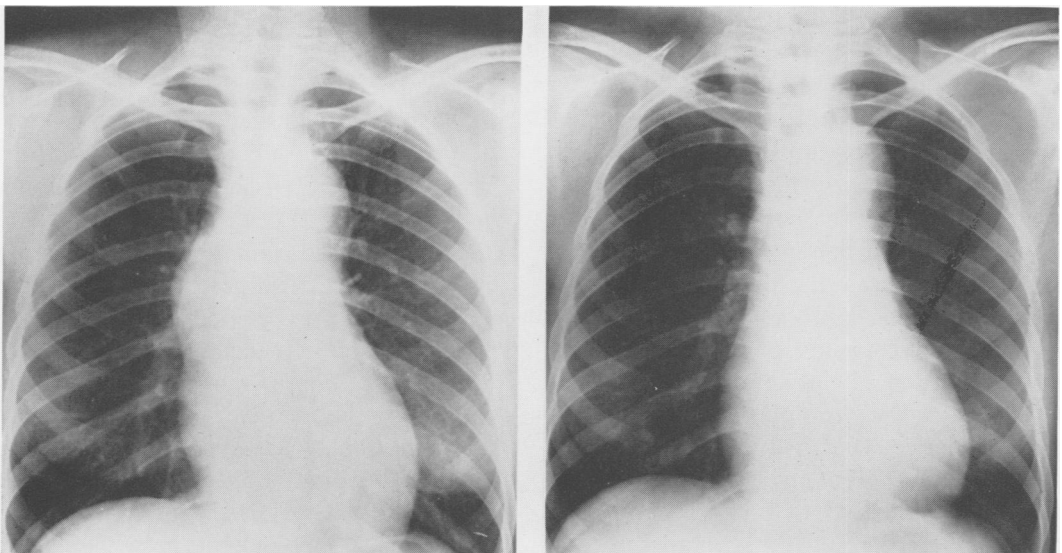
(c) (left) Preoperative roentgenogram. (d) (right) Postoperative roentgenogram.
